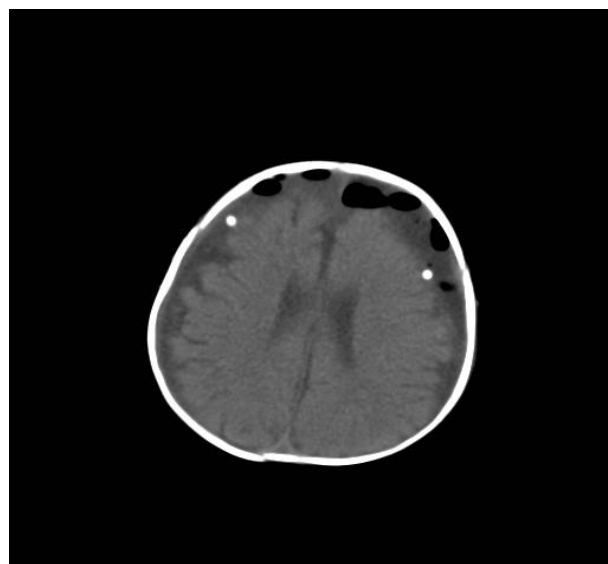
Postoperative CT scan in axial plane showing bilateral subdural drains
